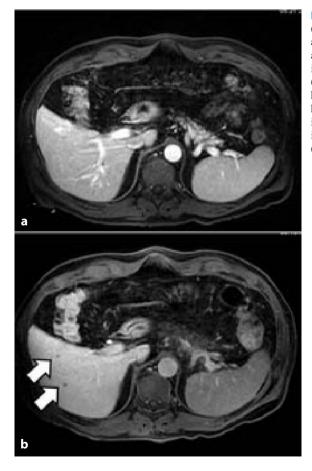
Two small metastases (arrows) of pancreatic adenocarcinoma in segments V and VI. They are hard to identify on portal phase images (a) but readily depicted as hypointense lesions in the hepatobiliary delayed (80 min) image after intravenous injection of contrast media (b) (gadobenate dimeglumine) In conclusion, imaging has shown significant improvements in the assessment of pancreatic cancer, particularly in view of pancreatic surgery. A close correlation between imaging as well as clinical and endoscopic findings (including endoscopic ultrasound) is often needed to establish the correct treatment.
